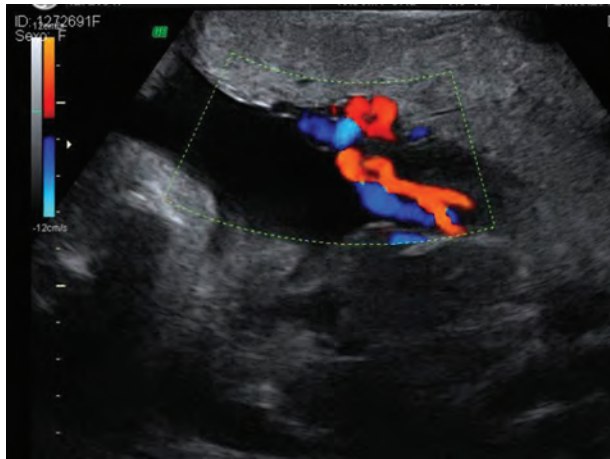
Ultrasound image at 32 weeks. Observe short umbilical cord.
